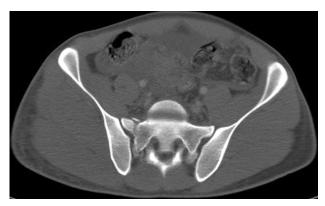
Pelvis CT. There is a displaced fracture of the right sacrum.
